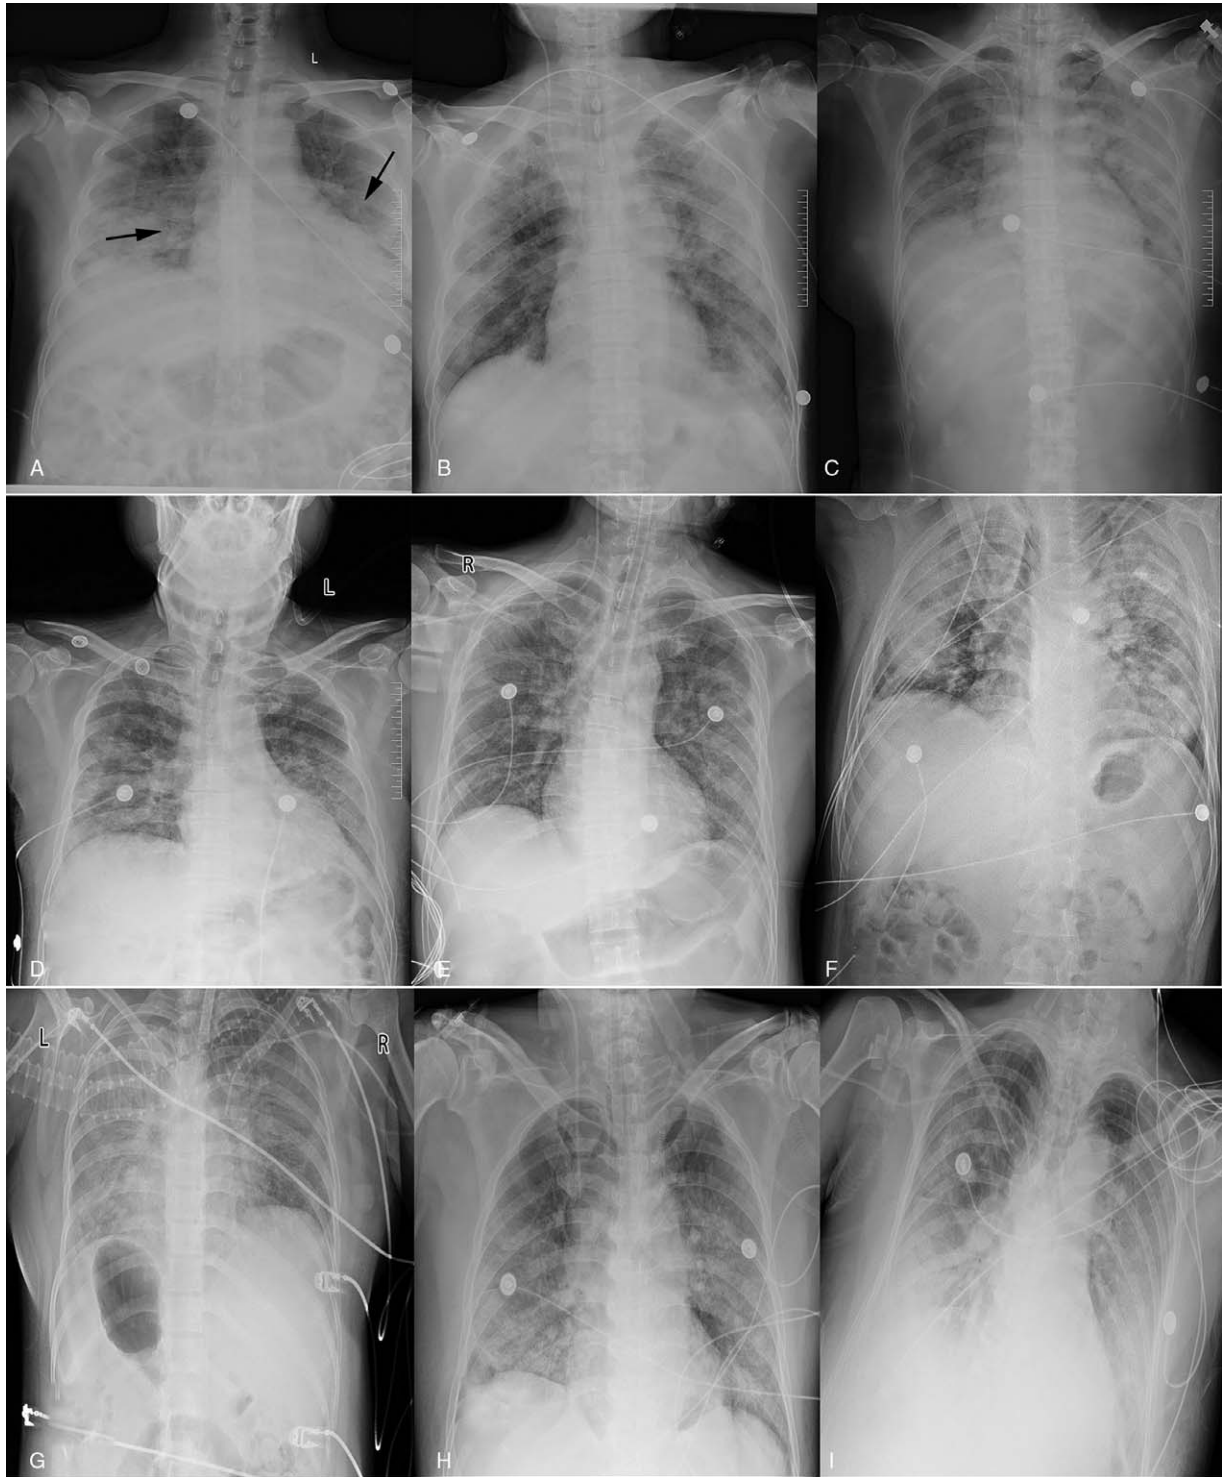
Chest radiographs of enrolled patients (2 patients are not acquired) on the day of intubation showing ground-glass opacity in the bilateral lung. Annotation: The arrow points show ground-glass opacity in the bilateral lungs of patient A.
